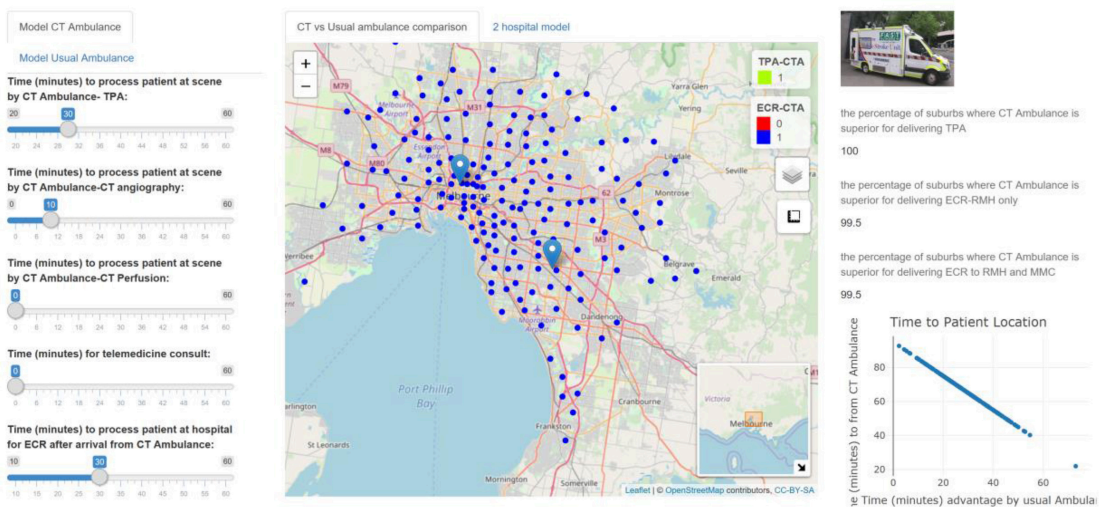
The apps contain widgets (on the left side) for varying variables of interest for MSU and usual ambulance. The suburbs in which MSU is superior to usual ambulance is displayed on the map as green (inferior as yellow). The viewer can switch the control box to display suburbs in which MSU is superior for returning to base at RMH to perform ECR (blue). The percentage of suburbs in which MSU is superior to usual ambulance is displayed on the right-hand side. Using CTA & on-board neurologist, MSU can reach 100% of suburbs for TPA.
